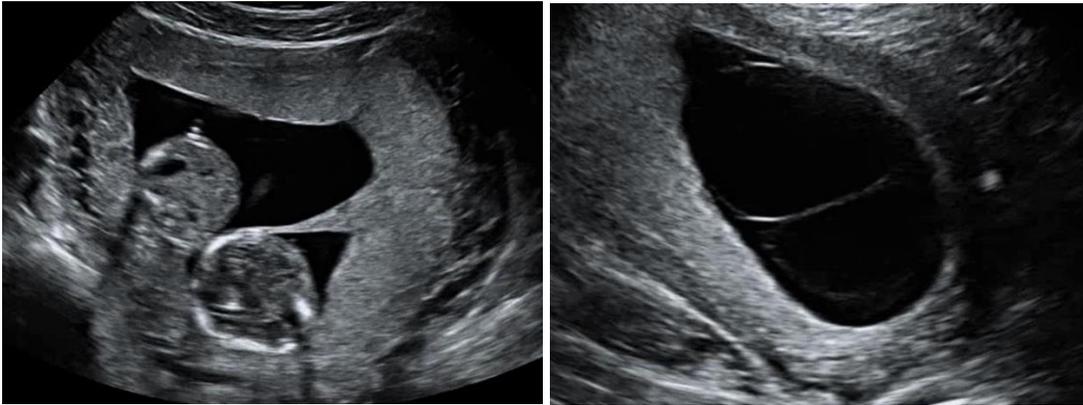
Ultrasound findings of lambda sign in a DC twin pregnancy (left) and T-sign in a MC twin pregnancy (right) at 12 weeks' gestation. ³⁶
